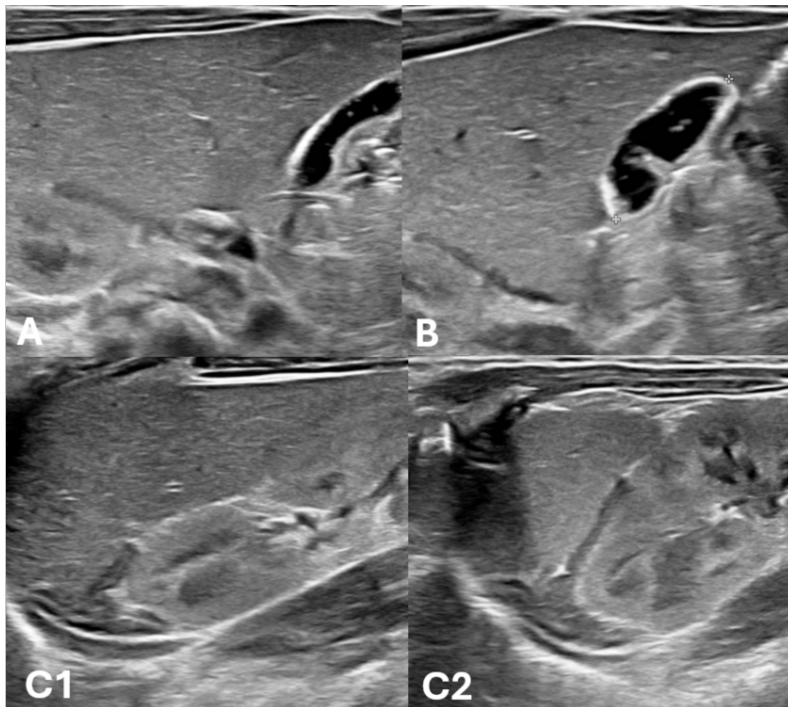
Ultrasound images showed normal for liver (A), gallbladder without any biliary tract abnormality (B), and both adrenal gland (C1: Right, C2: Left).
